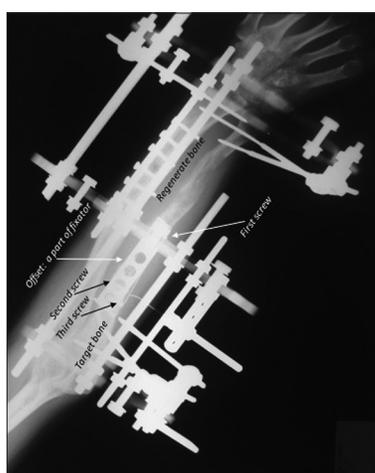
Postoperative anteroposterior radiographs of forearm of Patient 1 after 2 months from surgery
